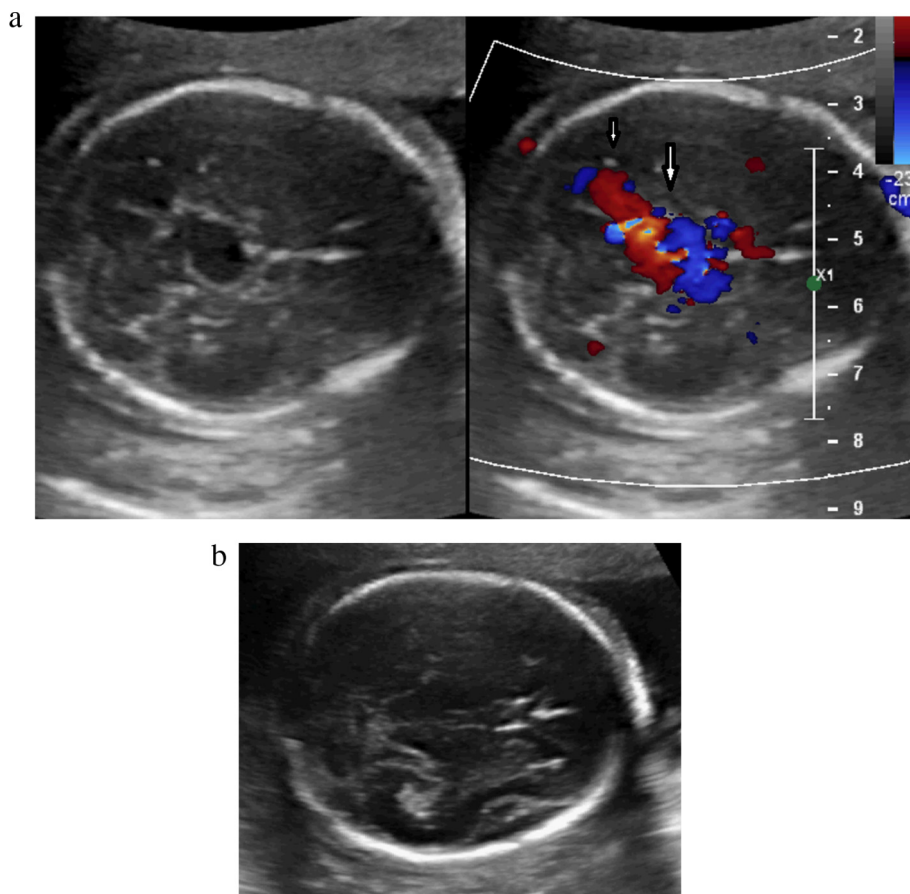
a: Gray scale and color Doppler sonography show pial AVF as a midline dilated venous pouch at the level of willis circle which fed by multiple dilated arteries (larger arrow) and was draining into a dilated superior petrosal sinus (smaller arrow). b: Axial view at the level of midbrain. No pathology was found at the quadrigeminal plate cistern.
